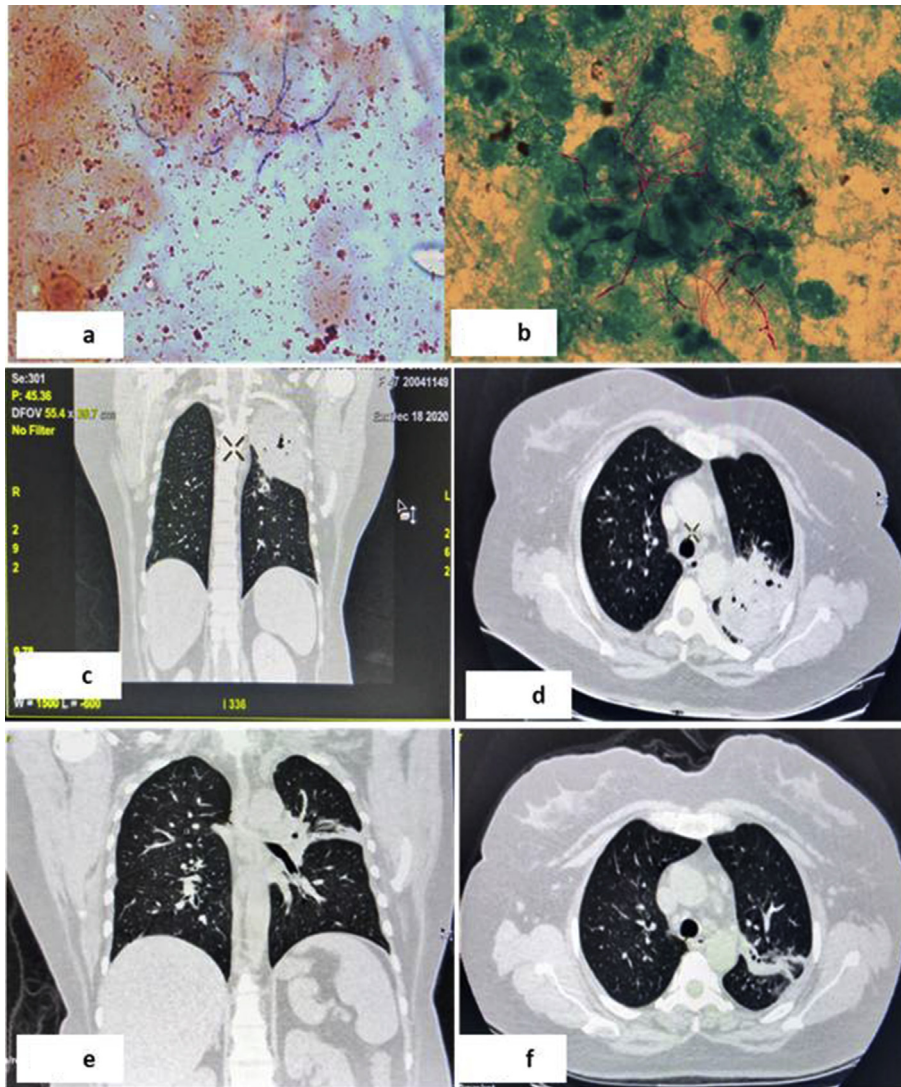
a–b:Gram positive and modified ZN smear showing acid fast branching filamentous structure, Fig. 1 c–d CT: mass.
